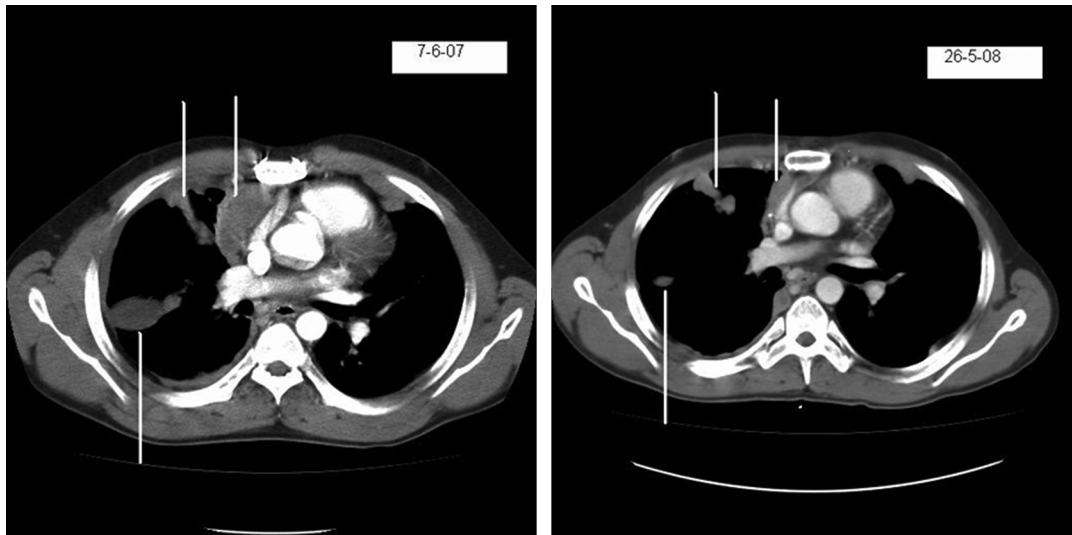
CT scans done at baseline (7/6/07) and after 17 cycles (26-5-08) of treatment with motesanib diphosphate showing reduction in pleurally-based masses.
